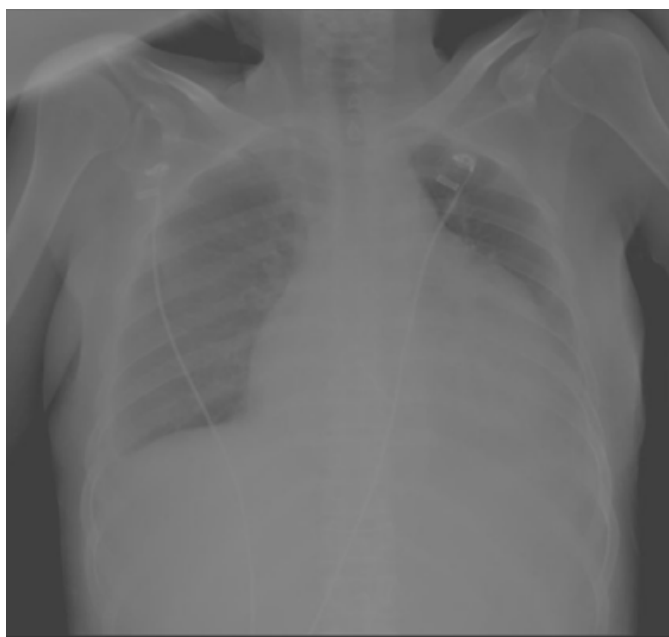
Chest-x-ray represents cardiomegaly
